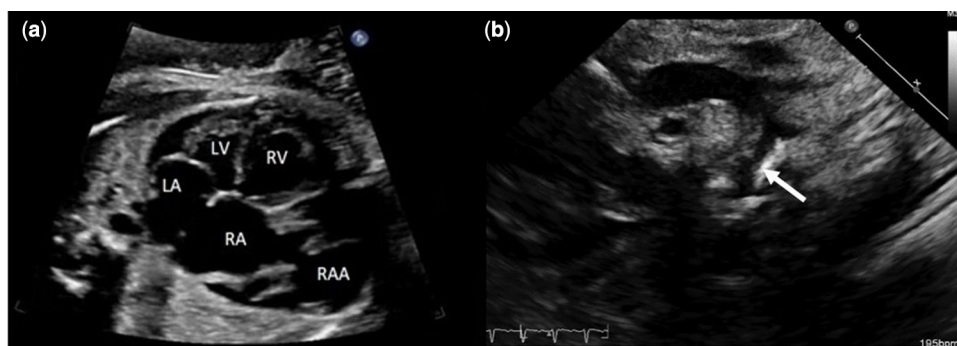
(a) Foetal echocardiogram showing the right atrial aneurysm (RAA). (b) Postnatal transthoracic echocardiogram showing coarctation of the aorta (white arrow).
